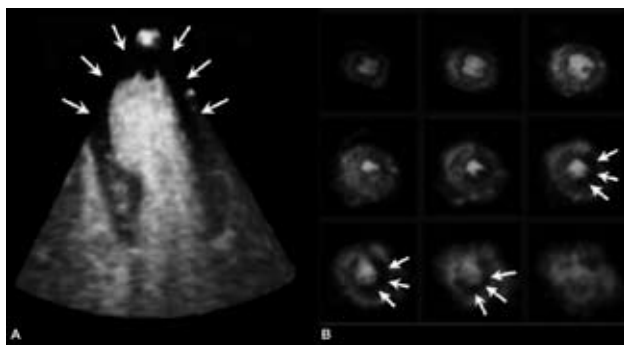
Examples of poor endocardial border definition during multiplane (triplane) 3D echocardiography (panel A, top) and during multislice 3D echocardiography (panel B, top). The use of intravenous echo-contrast significantly improves endocardial border definition (panel A and B, bottom), allowing the assessment of wall motion abnormalities.
